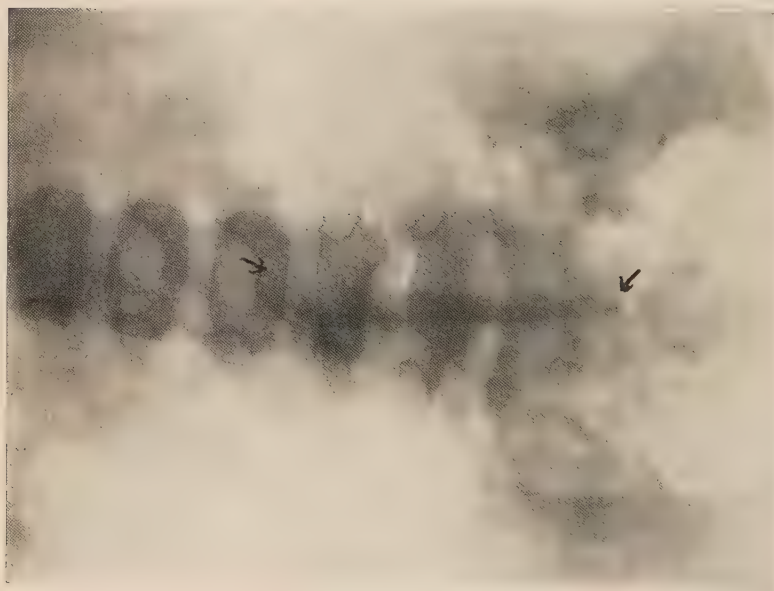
X-ray taken six months after operation. Case of acute Pott's disease. Child was kept on gas-pipe frame for seven weeks. Symptoms were immediately relieved after operation, and have remained so. Child runs about and plays like normal children.
